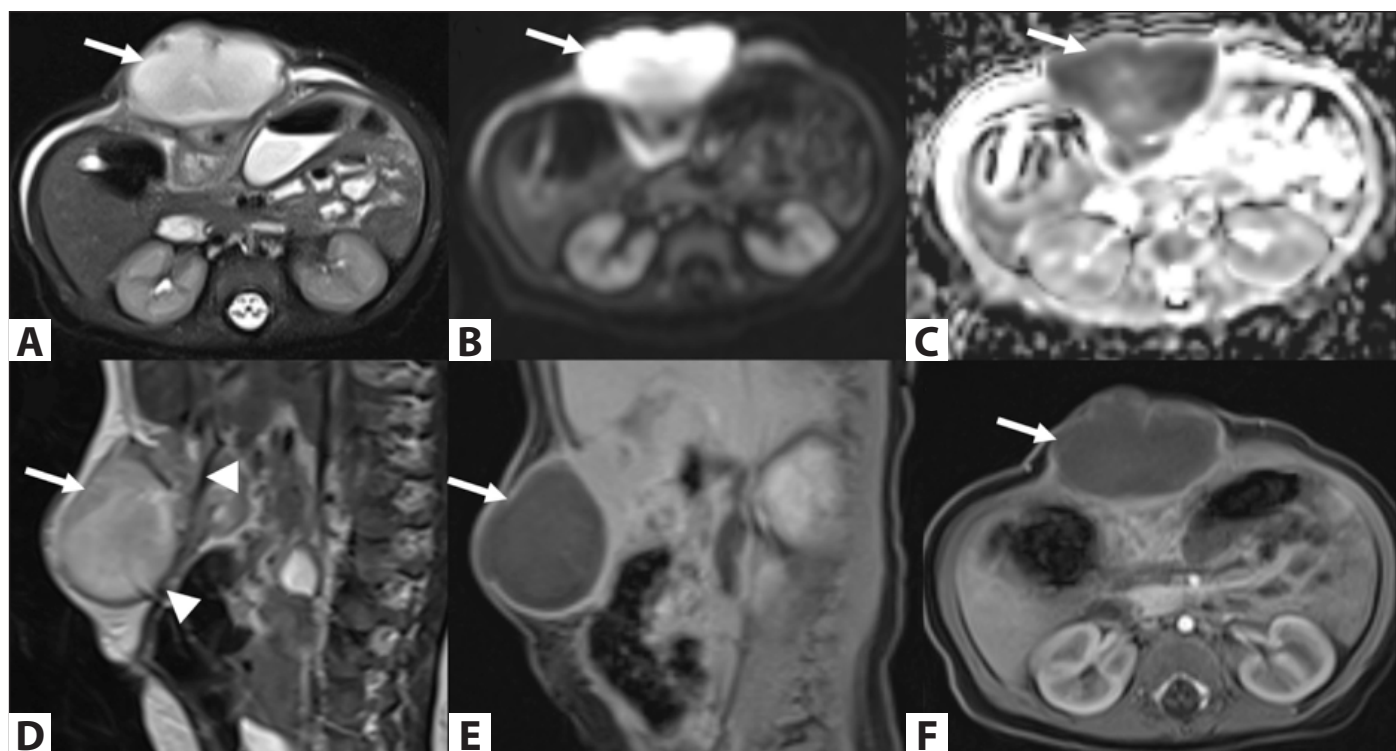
MRI examination. (A). On the axial T2-weighted image, a markedly hyperintense lesion is observed between the anterior surface of the liver and the anterior abdominal wall (arrow). (B). Diffusion-weighted imaging and (C). ADC map demonstrate diffusion restriction of the lesion, consistent with dense purulent content. (D). On the sagittal T2-weighted image, the ligamentum teres is identified posterior to the lesion as a hypointense linear structure (arrowheads). (E). Sagittal and (F). axial T1-weighted fat-suppressed contrast-enhanced images show peripheral contrast enhancement of the lesion (arrow).
